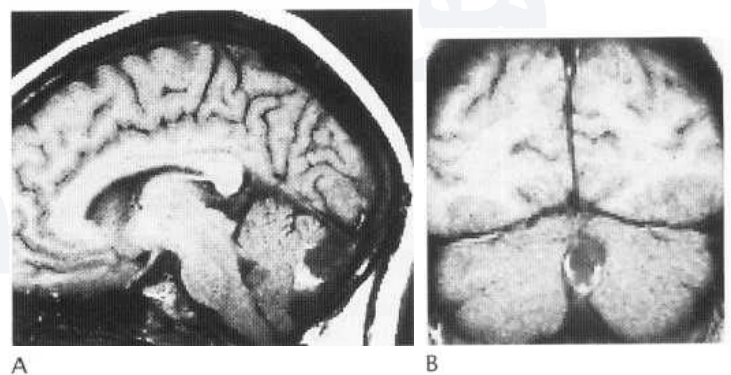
Dermoid. Sagittal (A) and coronal (B) MRI sections (T₁-weighted) demonstrate small ovoid mass in lower vermis with high signal in lower part and low signal in upper part.
